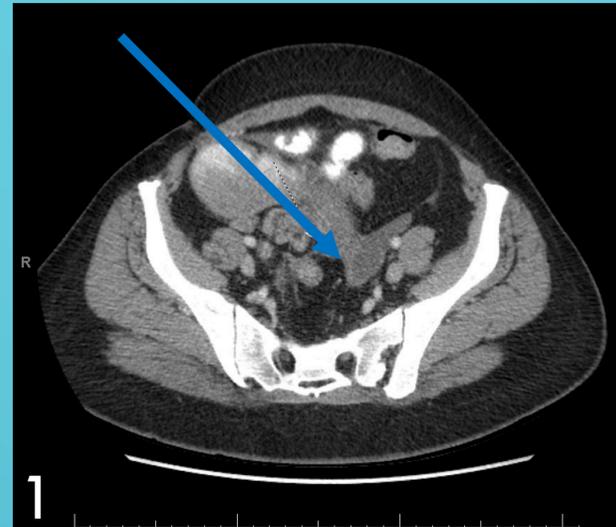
CT abdomen pelvis showed distension of the distal small bowel with corresponding thickening suspicious for small bowel obstruction (SBO).
